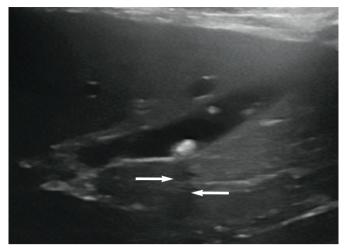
Ultrasound image showing the typical appearance of a cholelith. A well-defined hyperechoic structure is visible within the lumen of the gall bladder. Note the subtle acoustic shadow (arrows) distal to the stone as a result of mineralisation
